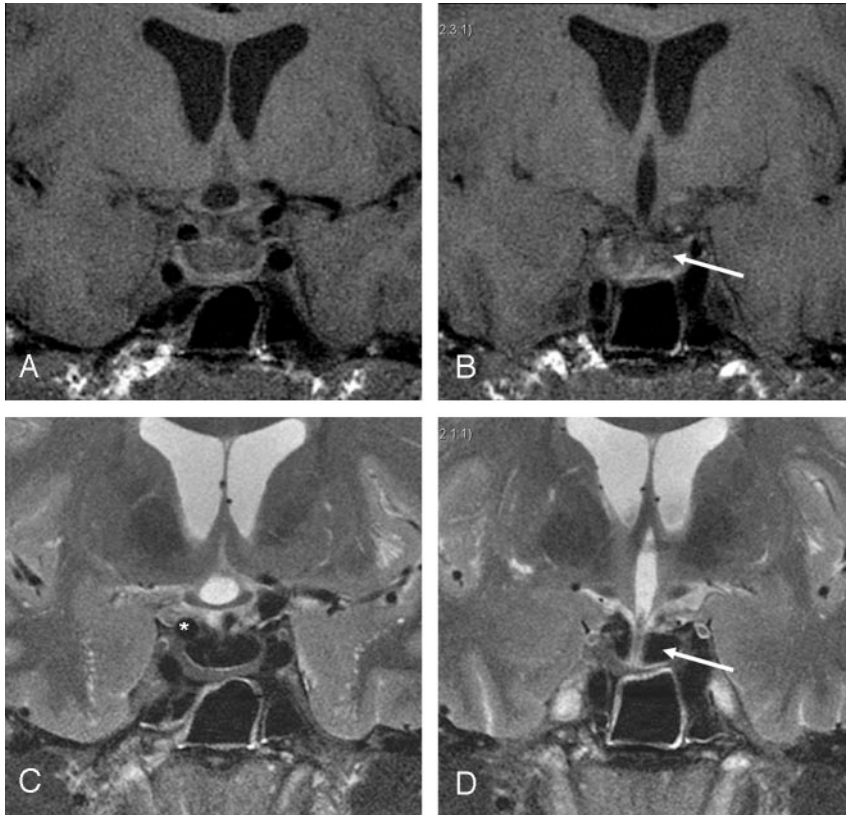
Coronal T1- and T2-weighted 3T MR imaging through anterior (A,C) and posterior (B,D) sella. C, Junction of aneurysmal neck and body (*), which projects partly superior to dural ring (interface with CSF) and partly inferior to the dural ring (interface with blood within sella). Note the large sella turcica filled with blood (arrows) showing homogeneous hypointensity on T2-weighted images and isointensity on T1-weighted images, consistent with intracellular deoxyhemoglobin. Note that the blood in the suprasellar cisterns has different signal intensity. D, The infundibulum can be traced to the compressed pituitary.
